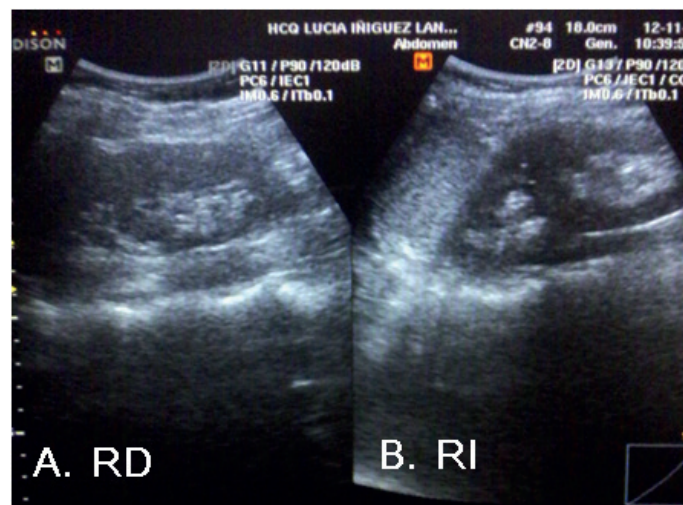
Renal ultrasound: kidneys of normal size and echogenicity, appearing to have an uncomplicated double excretory system
